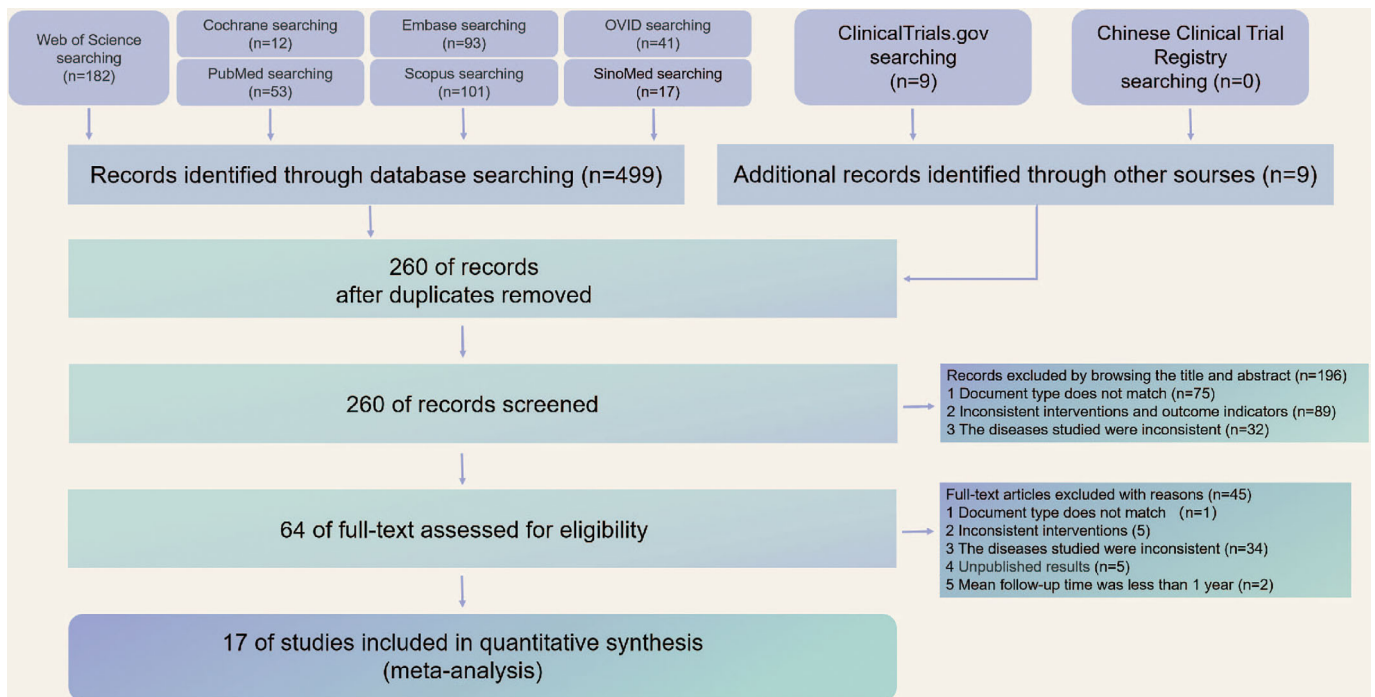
PRISMA flow-chart for systematic review identifying articles reporting long-term clinical and radiographic results of oblique interbody fusion for degenerative lumbar spondylolisthesis
